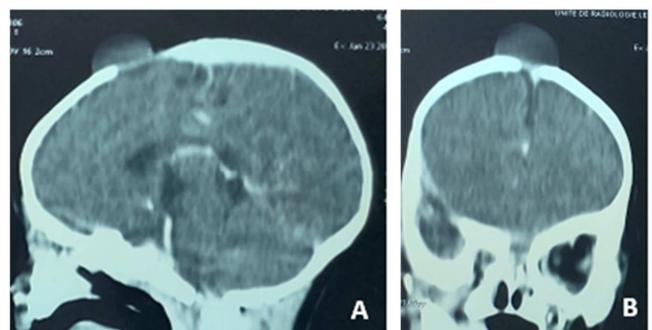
Cranio-cerebral CT in sagittal (A) and coronal (B) reconstruction showing an isodense cystic subcutaneous lesion of the Anterior Fontanelle without endocranial extension.
